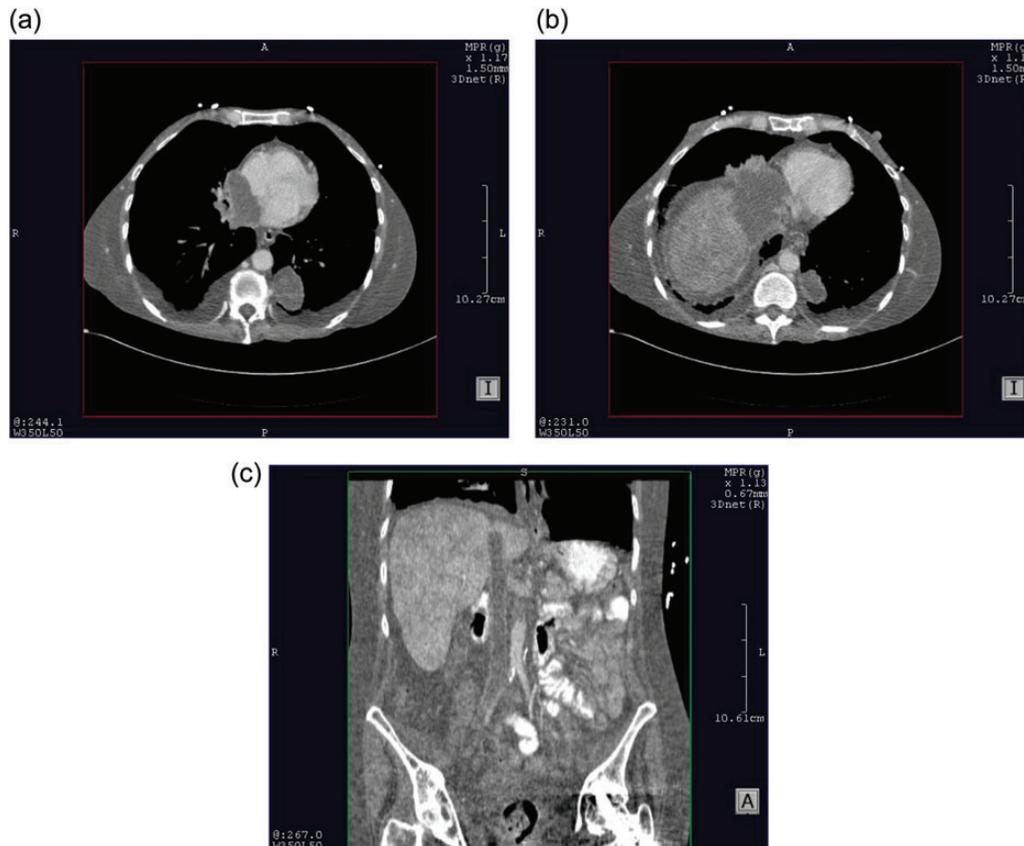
(a) Axial CT image, which shows a soft tissue mass invading the right atrium, a left retrocardiac lung mass and small bilateral pleural effusions. (b) An axial CT image that shows the extent of the right cardiophrenic mass, which invades the right atrium, liver and hemidiaphragm. The IVC is obstructed by this mass. (c) Coronal CT image, which shows a large filling defect within the IVC consistent with a thrombus.
